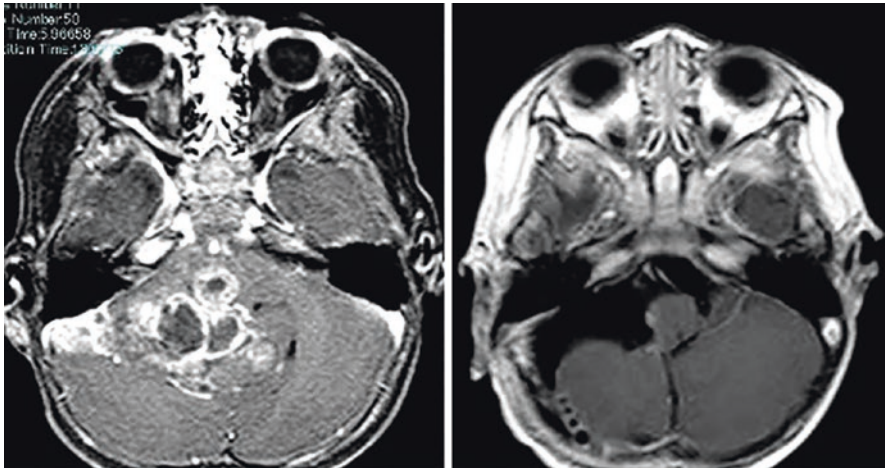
A case of anaplastic ependymoma in a 2-year-old boy. Left: Preoperative Gd-enhanced MRI demonstrated the tumor extending from the right cerebellopontine angle to the ventral side of the brainstem. Right: Postoperative Gd-enhanced MRI showed gross total resection of the tumor. A small part of the tumor remained on the right lateral surface of the brainstem
